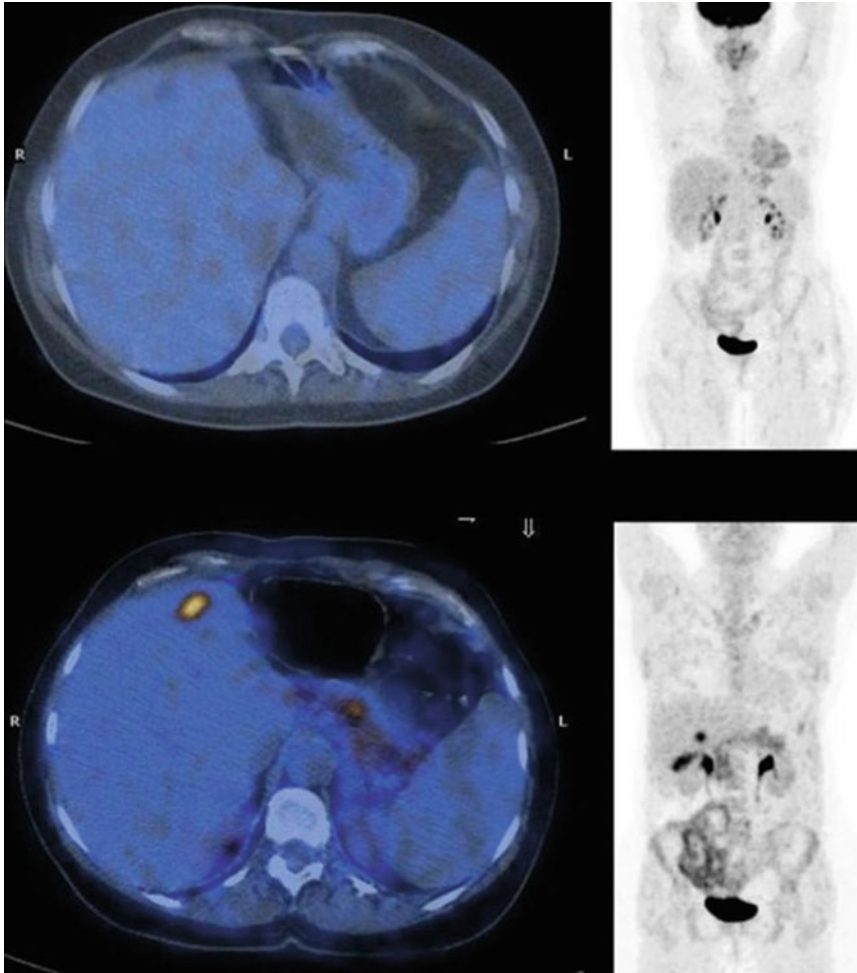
MIP images of ^{18}F -FDG PET/CT (upper image) and ^{18}F -DOPA PET/CT (lower image), with transversal views demonstrating a single small liver metastasis derived from a previously operated intestinal carcinoid; the lesion is visible only on the ^{18}F -DOPA images and appears undetectable on ^{18}F -FDG PET/CT
